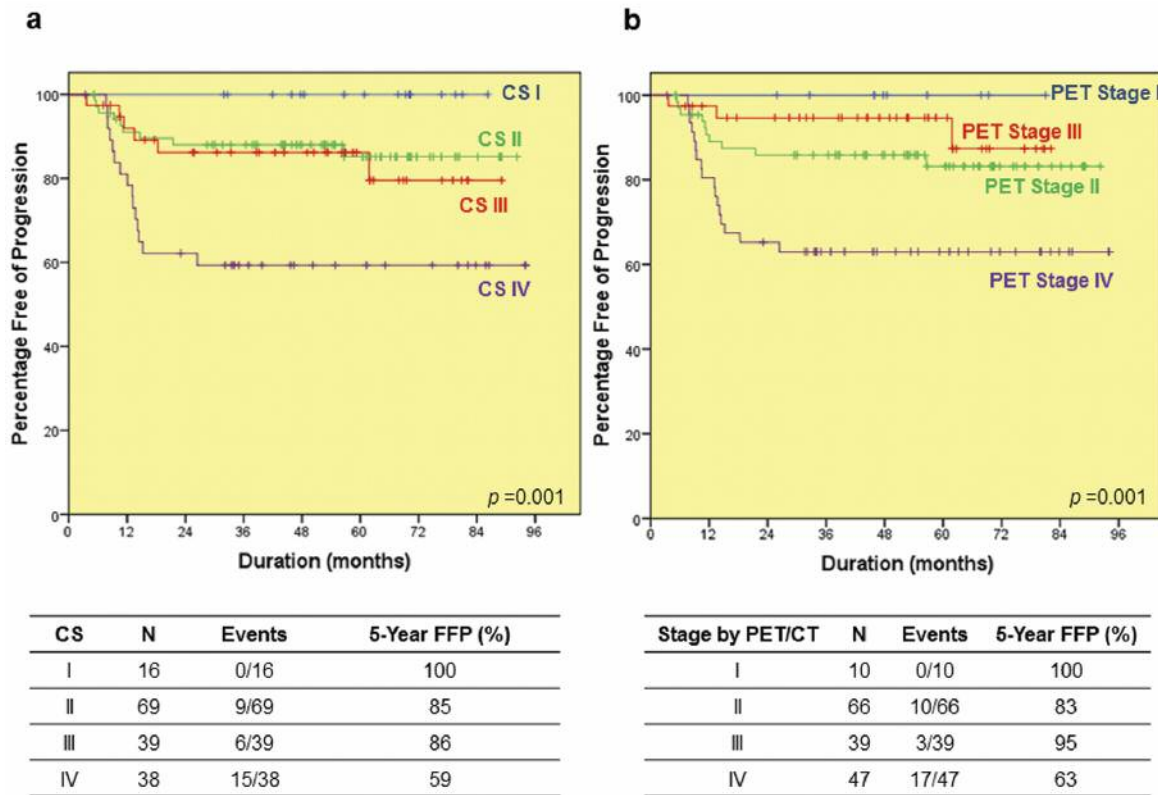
Freedom from progression according to clinical stage (CS) (a), and stage by positron-emission tomography/computed tomography (PET/CT) (b).
